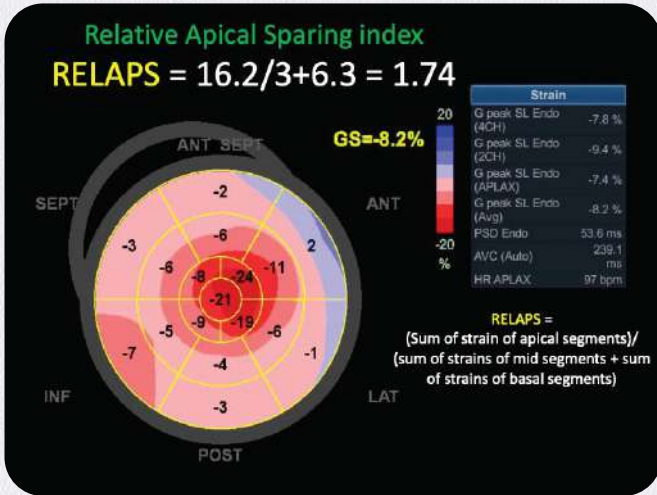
LV Apical sparing- Speckle tracking echocardiography shows a bulls-eye plot of the left ventricular (LV) regional segments. The mid and basal segments are pink, indicating very low segmental strain. In comparison, note the apex, which is red, indicating better segmental strain. This is called LV apical sparing. The global longitudinal strain (GLS) is severely reduced (GLS=-8.2%). A high LV ejection fraction (EF) to global longitudinal strain (GLS) ratio of >4 is highly specific for cardiac amyloid.
